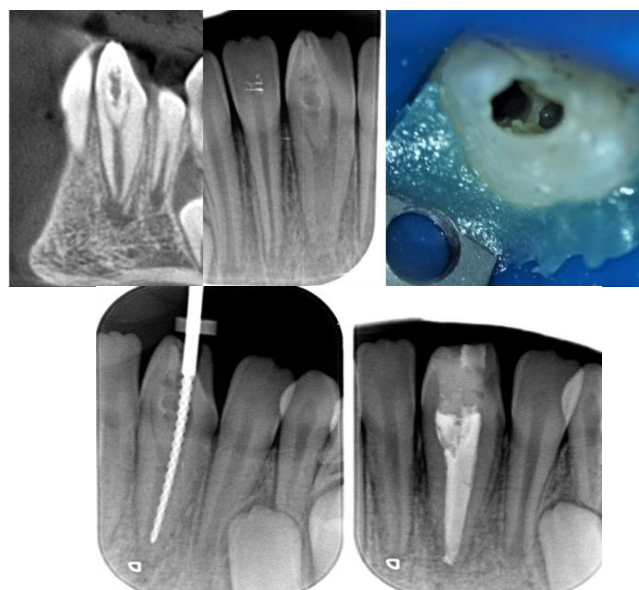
A periapical lesion in the 31 tooth with Type II Invagination. X-ray of the WL measurement and post op X-ray.
